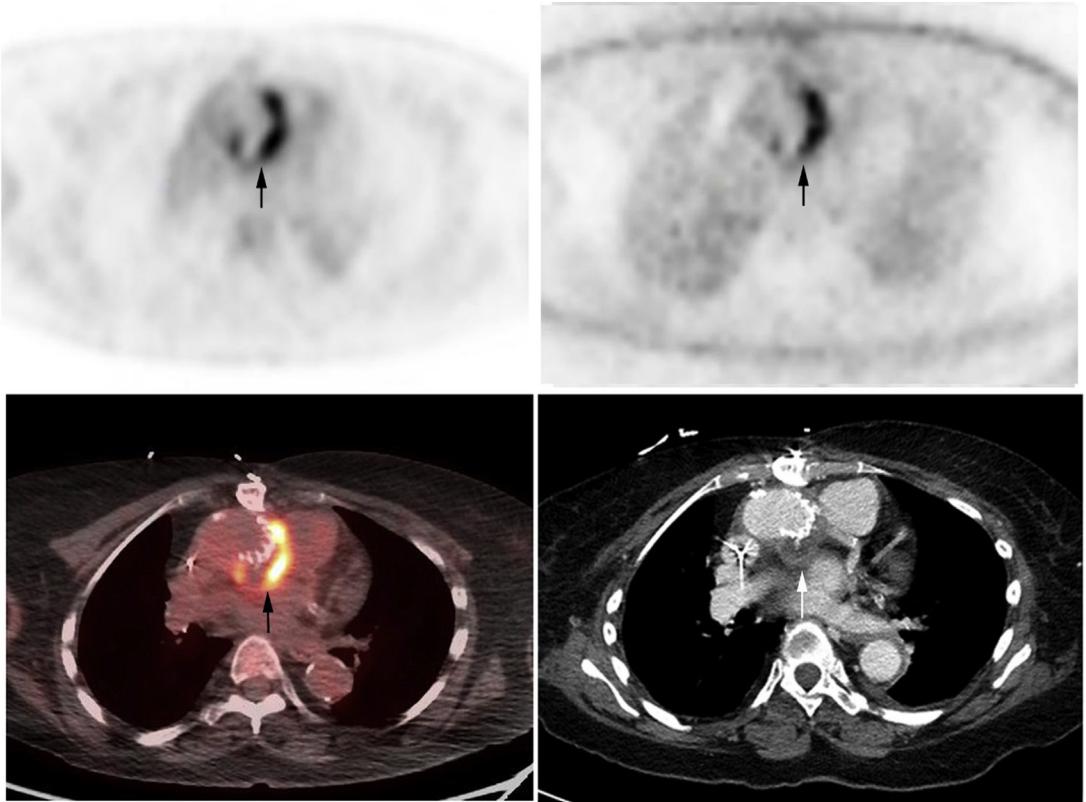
Attenuation corrected (*top left*), non-attenuation-corrected (*top right*), fused PET/CT (*bottom left*), and CT (*bottom right*) images demonstrate prominent hypermetabolic activity involving and surrounding the infected transaortic valve prosthesis with a perivalvular fluid collection/abscess (*arrows*) in a patient with methicillin-resistant *Staphylococcus aureus* bacteremia.
